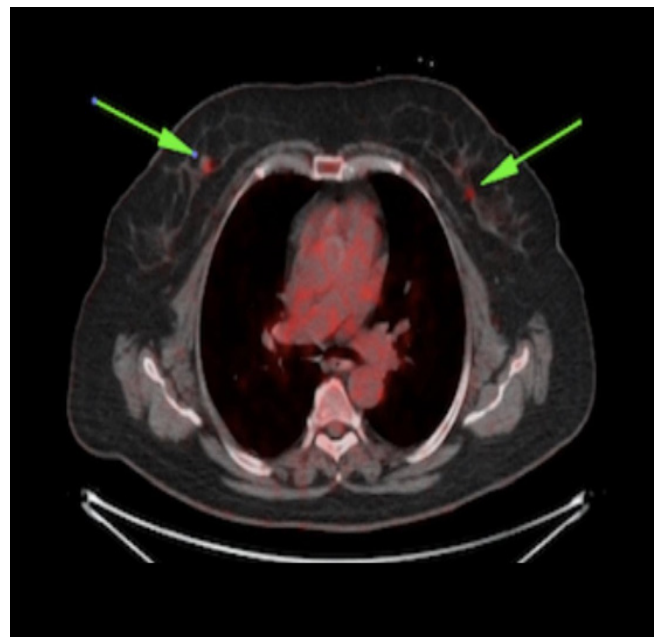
PET/CT scan showing FDG uptake in both breasts.
